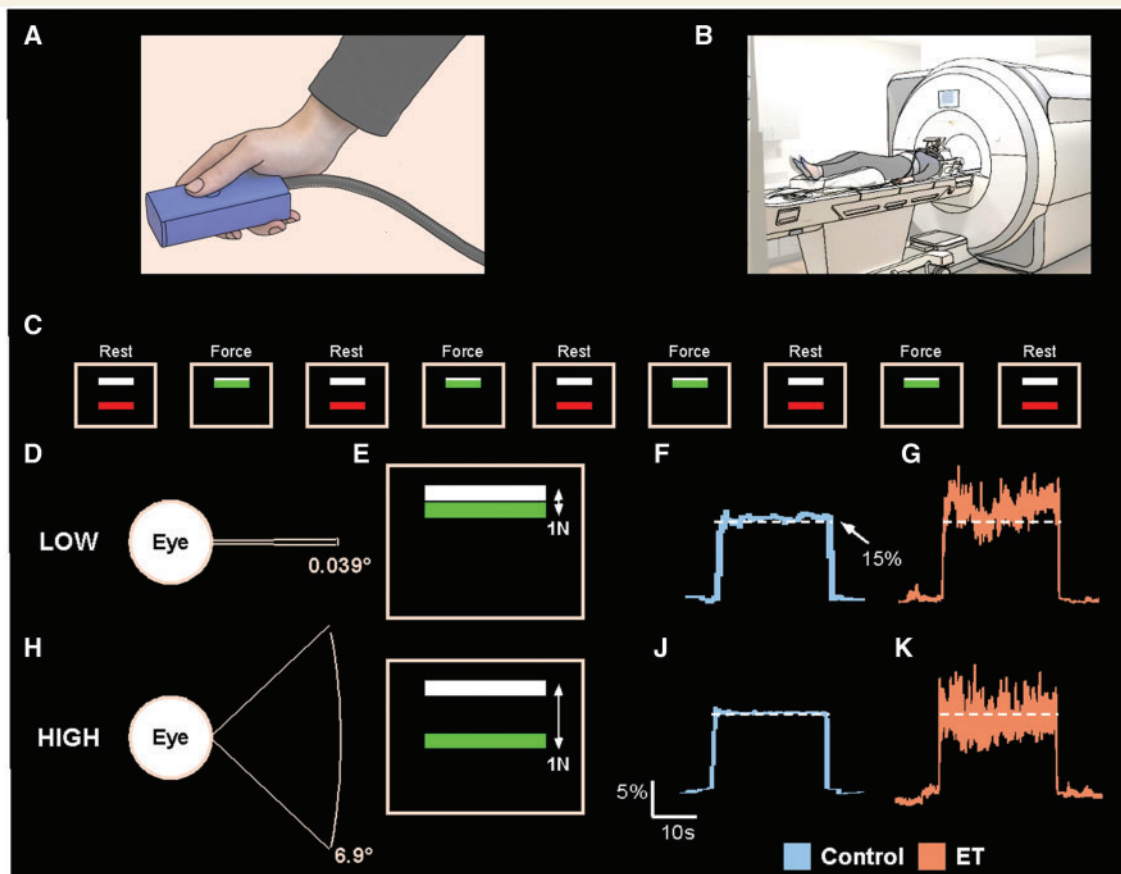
Experimental set-up. The force transducer was held between the thumb and the index finger by the participant during the MRI session (A), and the participant laid in the supine position in which the hand and transducer rested on the upper leg (B). Above the field of view of the participant was a mirror, which reflected the visual display. The visual display instructed the participant when to produce force. Initially, the participant rested for 30 s in the ‘Rest’ condition (C). At the end of the Rest condition, the colour of the bar would change, indicating the beginning of the ‘Force’ condition. The participant then began producing force for 30 s, thus fluctuating around the white target bar. At the end of the 30 s, the colour of the bar would change again, indicating the beginning of the ‘Rest’ condition. An example showing the visual gain manipulation (D and H), how it is perceived by the subject on the visual display (E and I), and example force traces for a control subject (F and J) and an essential tremor (ET) subject (G and K) is also shown for the low and high visual feedback conditions.
